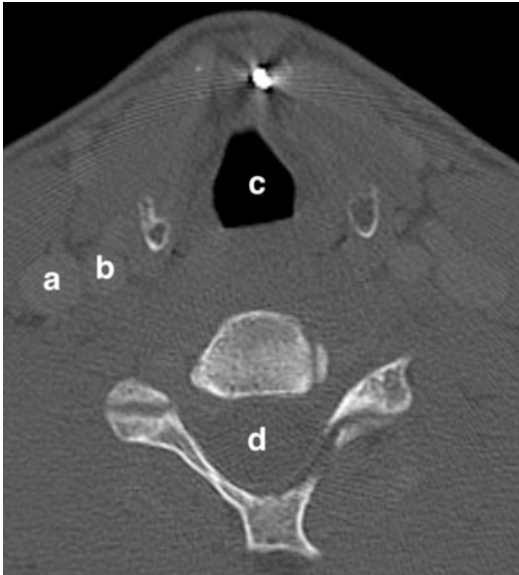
An axial Computed Tomography scan of the neck with energised fragment lodged in neck demonstrating structures with little inherent anatomical protection: *a* jugular vein, *b* carotid artery, *c* trachea, *d* spinal cord
